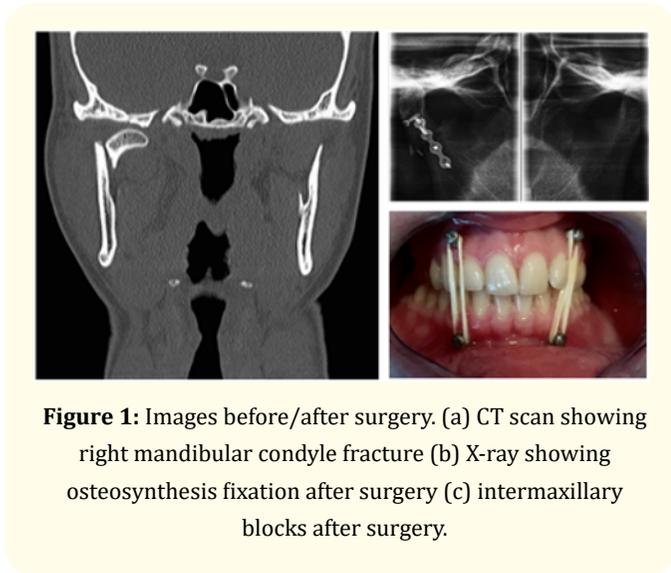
Images before/after surgery. (a) CT scan showing right mandibular condyle fracture (b) X-ray showing osteosynthesis fixation after surgery (c) intermaxillary blocks after surgery.
